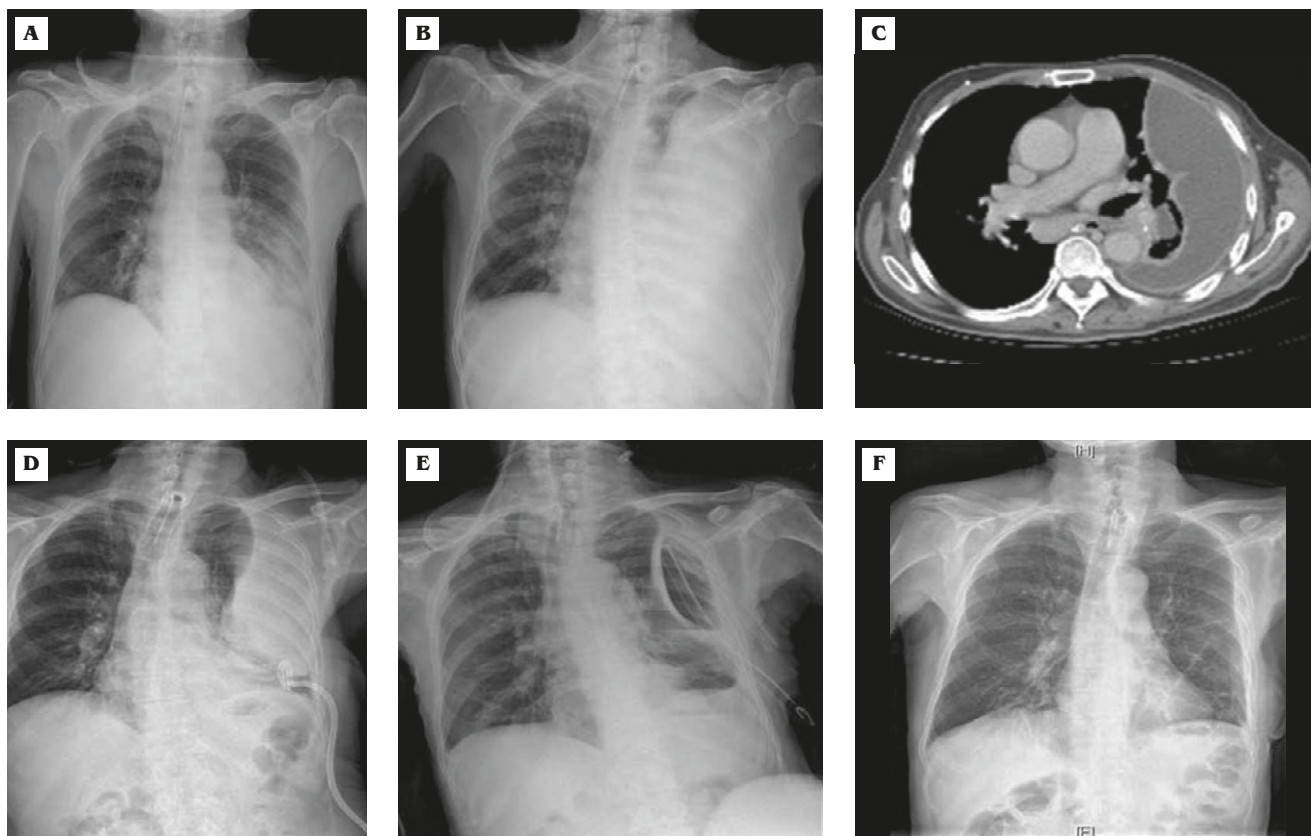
(A) Chest radiography at presentation shows a pneumonic patch over the left lower lobe and a tracheostomy tube in place. (B) A huge encapsulated pleural effusion occupying nearly the entire left pleural cavity, with the midline shift seen on subsequent chest radiography. (C) Chest computed tomography scan demonstrates encapsulated fluid collection and partial collapse of the left lung. (D) Chest radiography shows inadequate drainage following pigtail catheter insertion. (E) Diffuse thick peel hampering the left lung and huge cavity formation after chest tube drainage. (F) Chest radiography 3 months after surgery shows re-expansion of the left lung.
